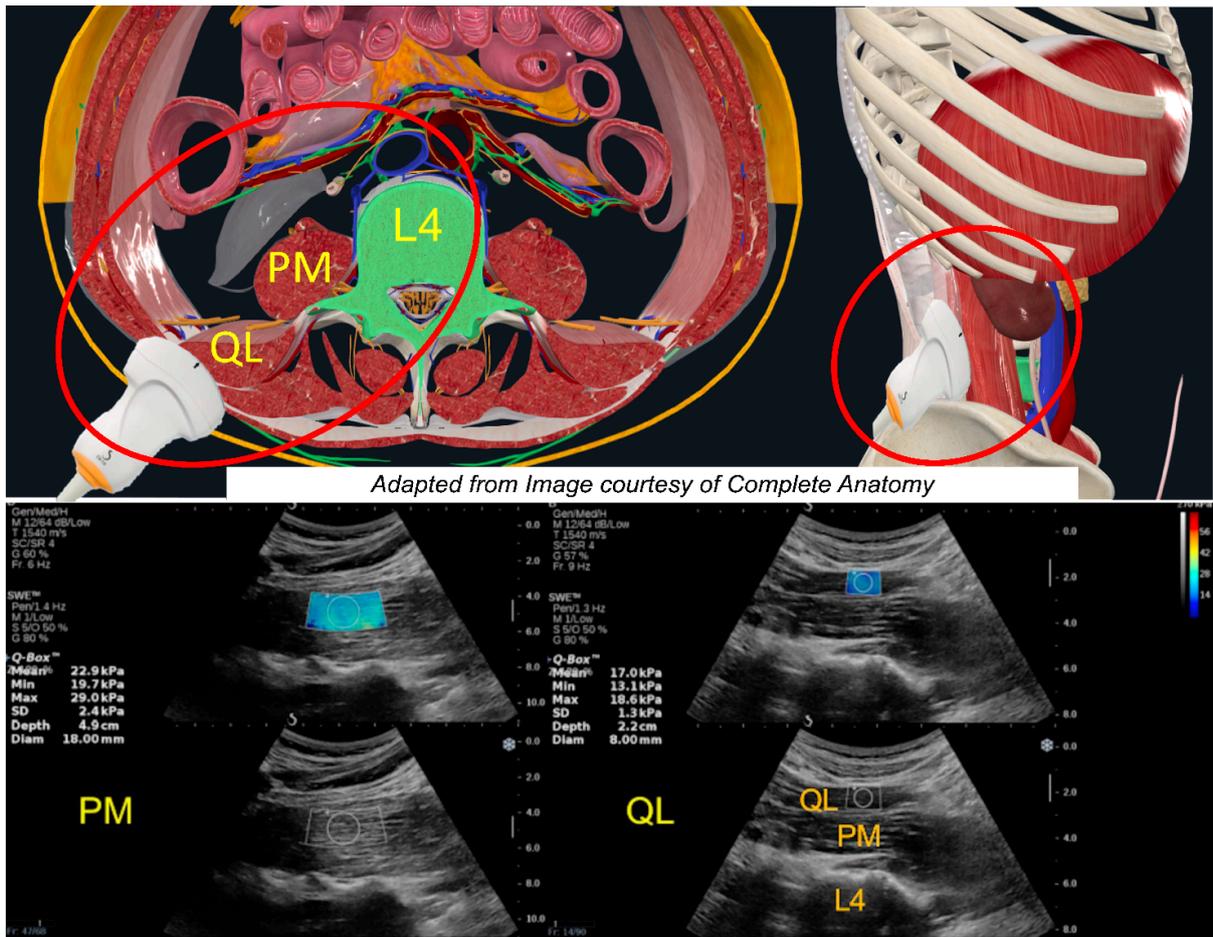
3 Anatomical adjacencies and ultrasound shear wave elastography measurement of psoas major (PM) and quadratus lumborum (QL)
